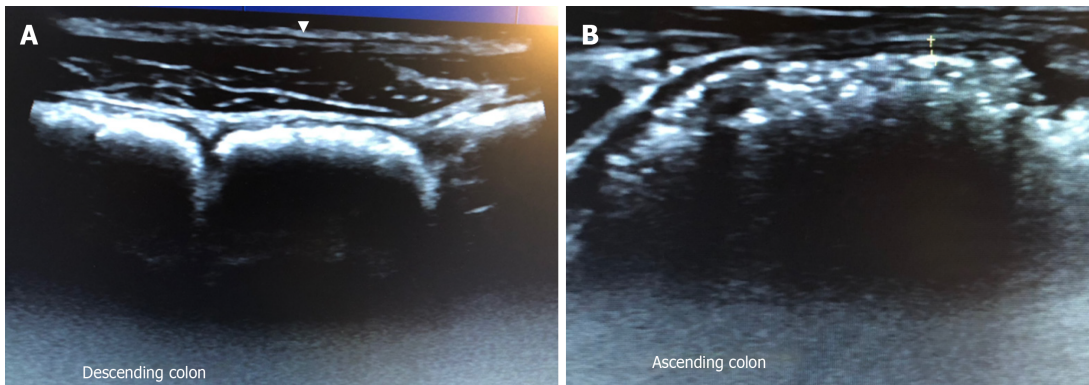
Gastrointestinal ultrasound images. A: Gastrointestinal ultrasound images of descending colon showing hausta-shaped reflections with acoustic shadow behind, suggestive of severe faecal loading B: Gastrointestinal ultrasound images of strong reflection with acoustic shadow behind, also suggestive of faecal loading.
